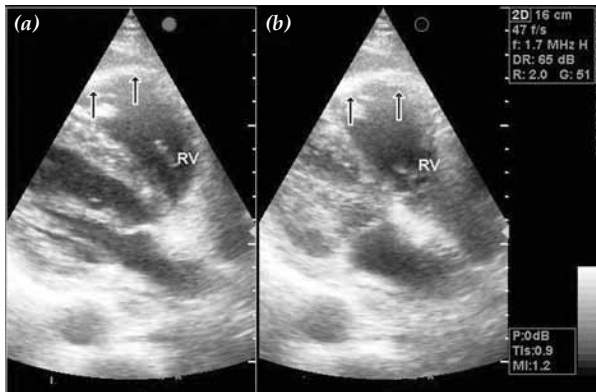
Apical 4-chamber view of right ventricle in diastole (a) and systole (b) two days after admission showing mild hypokinesia of RV apex and midfree wall.
